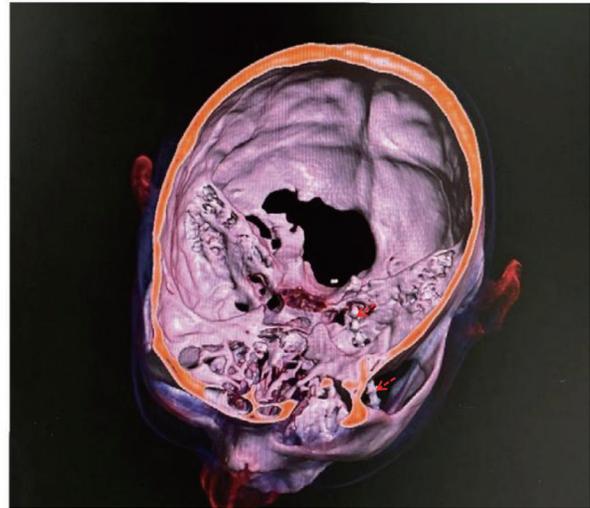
CT scan showing the stimulation lead positioned at the Gasserian ganglion. (A) Intracranial-connected white beads indicate the SCS-implanted electrode. The red arrow points to the stimulation electrode. (B) Three-dimensional reconstruction of the puncture approach. The white beads in the figure are SCS-implanted electrodes. The red arrow points to the stimulation electrode. CT, computed tomography; SCS, spinal cord stimulator.
